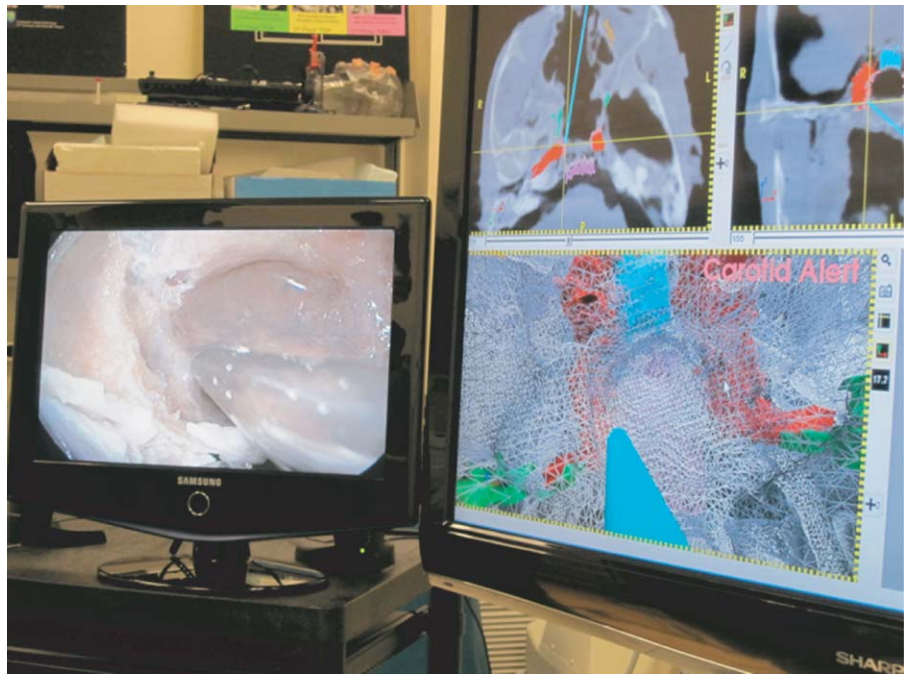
The drill tip has entered the carotid alert zone as shown in the virtual and cross-sectional views. An auditory alert reminiscent of an arterial Doppler trace is triggered when the drill is positioned in this zone to provide structure-specific proximity information.
